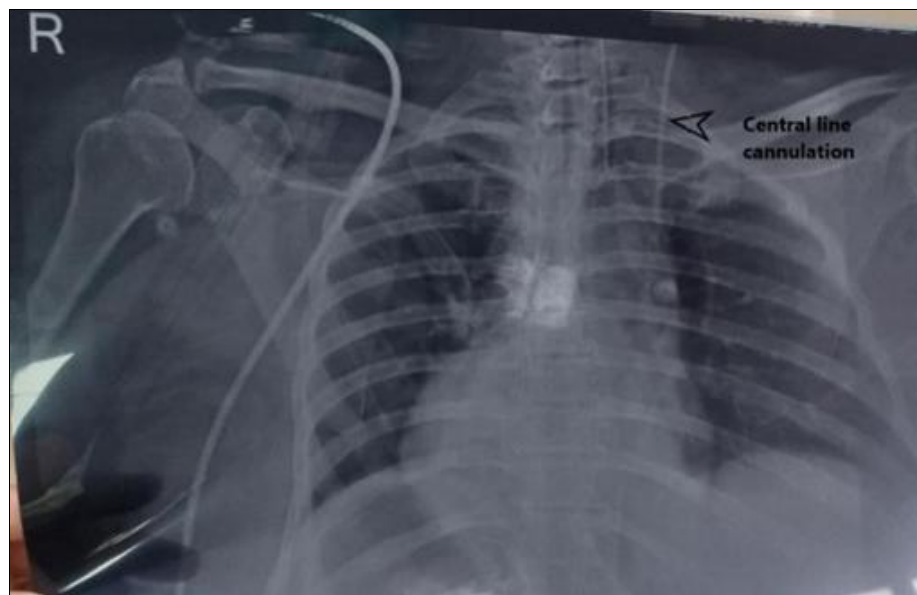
Chest radiograph showing cannulation of left IJV
